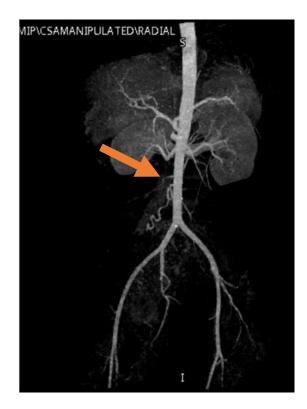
CT angiogram showing the origin of the artery supplying the placenta previa directly from the aorta just above the origin of the inferior mesenteric artery as shown by the arrow
